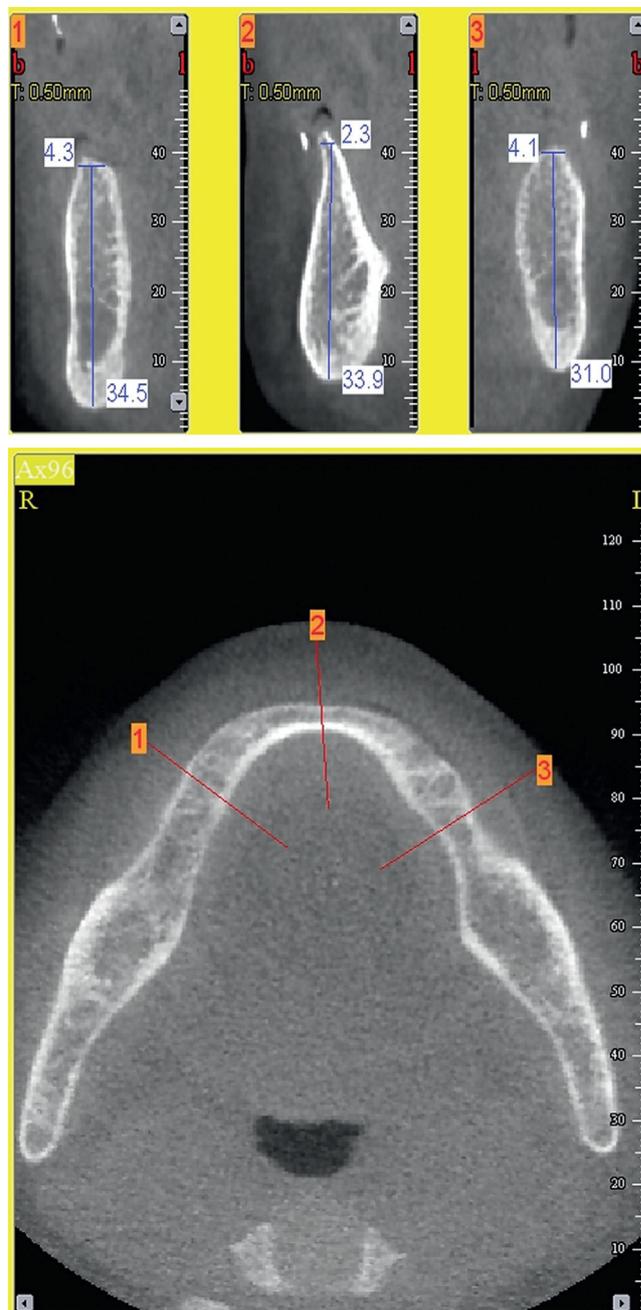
Top, Representative mandibular residual ridge computed tomographic scan. Bottom, Denture radiopaque inserts for site specific height and width measurement.
